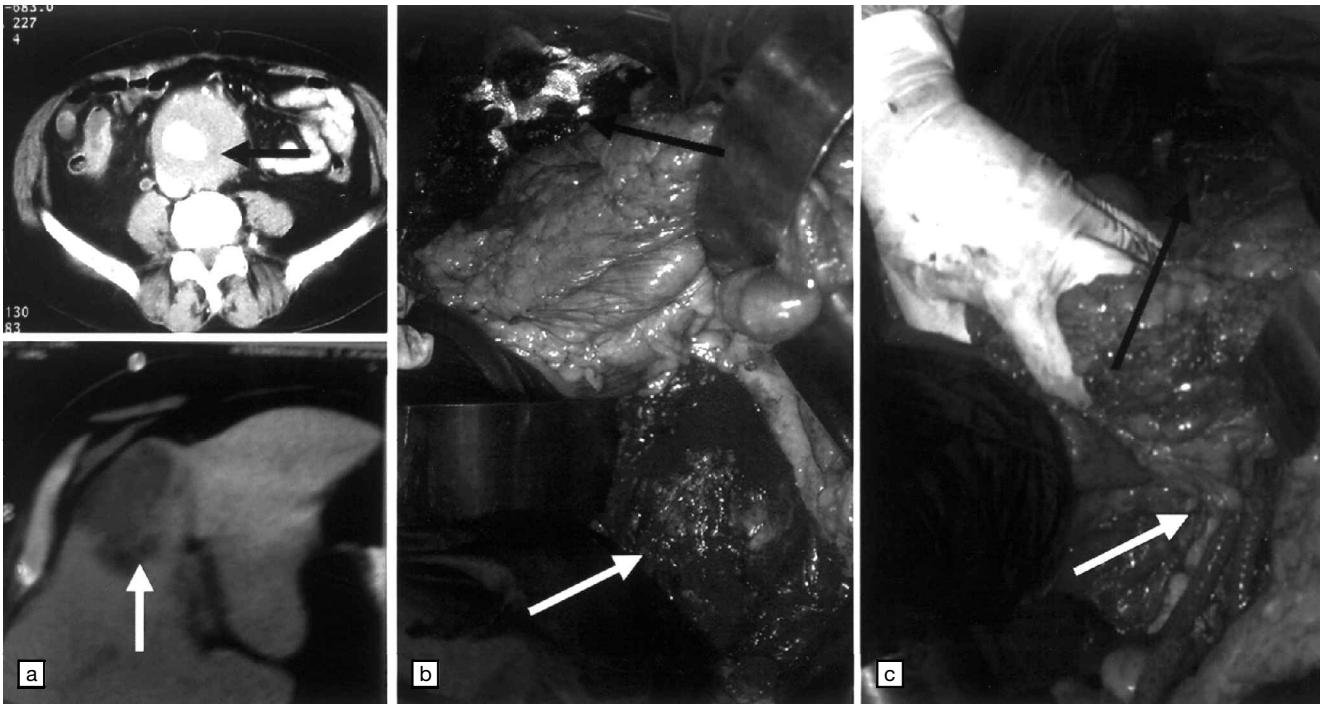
(a) CT scan of the abdomen showing the liver tumor (white arrow) and the AAA (black arrow). (b) Intra-operative images of the liver resection (black arrow) and the aneurysm (white arrow). (c) Intra-operative images of the liver resection (black arrow) and aorto-bi-iliac graft (white arrow).
